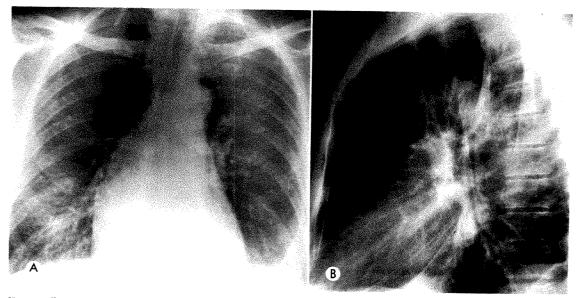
Case III. (A) Frontal teleroentgenogram of the chest showing an enlarged cardiac silhouette and bilateral pleural effusion. (B) Lateral roentgenogram showing that the cardiac shadow extends to the sternum.
